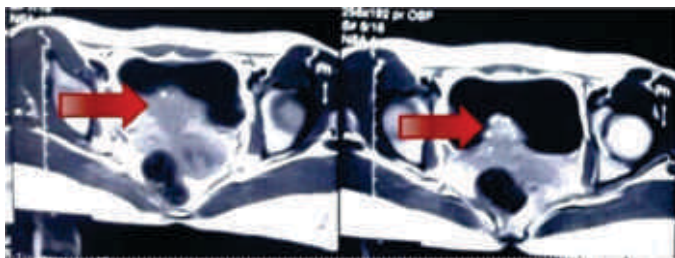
MRI of patient showing Vesical Endometriosis
